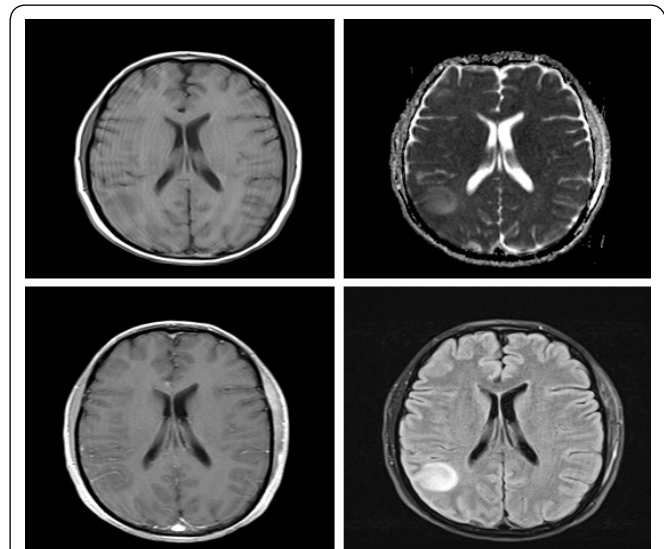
MRI brain A. T1 without contrast B. T1 with contrast C. ADC D. FLAIR.
